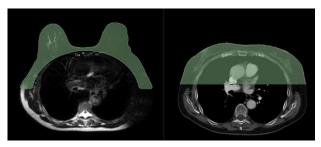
MRI and CT masks are aligned in the transversal plane. An approximate automatic segmentation of pectoralis muscle boundary is performed in the MRI image. Finally the prone and supine surfaces are extracted and modeled as triangular meshes.
